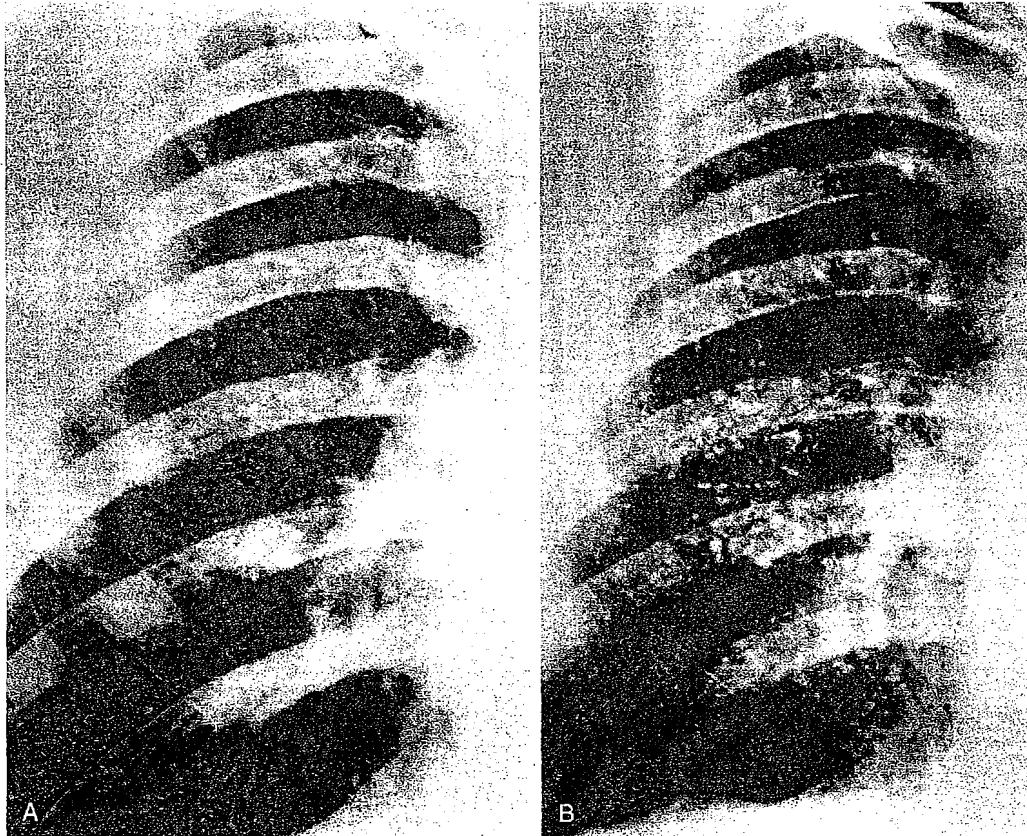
Calcification of Silicotic Nodules. A view of the right hemithorax from a posteroanterior radiograph of a 32-year-old man (A) reveals involvement of all lung zones by small irregular opacities of unit density. Eighteen years later (B), multiple punctate calcifications had developed throughout the right lung, representing calcification of the silicotic nodules. The patient had a history of 26 years' work in South African gold mines. (Courtesy of Dr. Raymond Glynn-Thomas, Medical Bureau for Occupational Diseases, Johannesburg, South Africa.)
